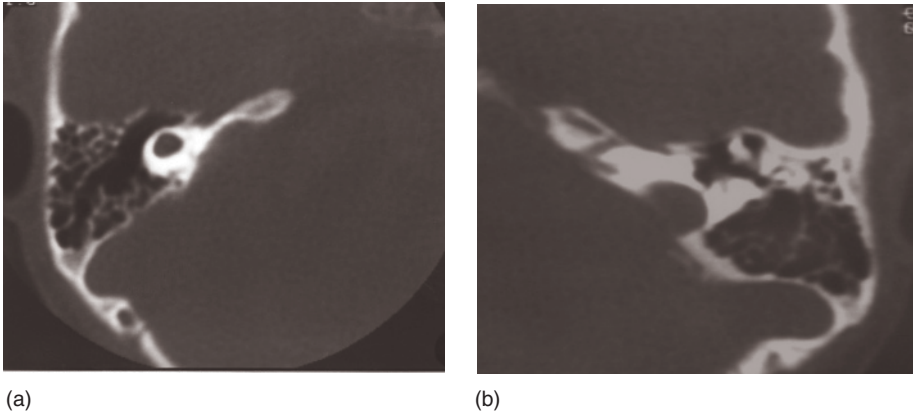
CT scan showing (a) severe dysplasia (primitive otocyst) on right side and (b) total cochlear agenesis on the left side (same patient).
